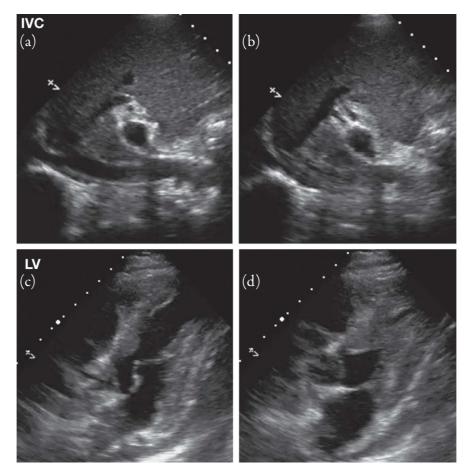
Inferior vena cava respiratory variability (a, b); apical five chamber window during diastole and systole (c, d).
